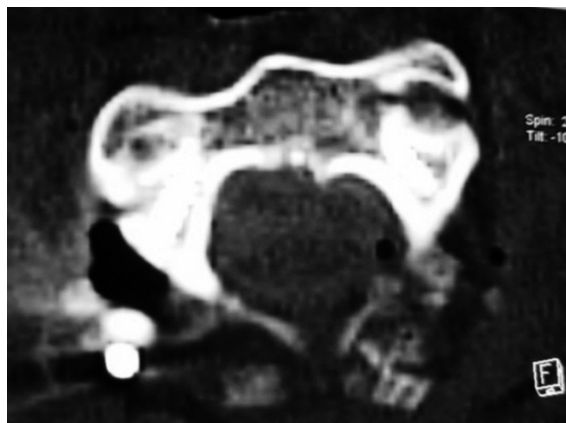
Post-op cervical CT (axial images).
